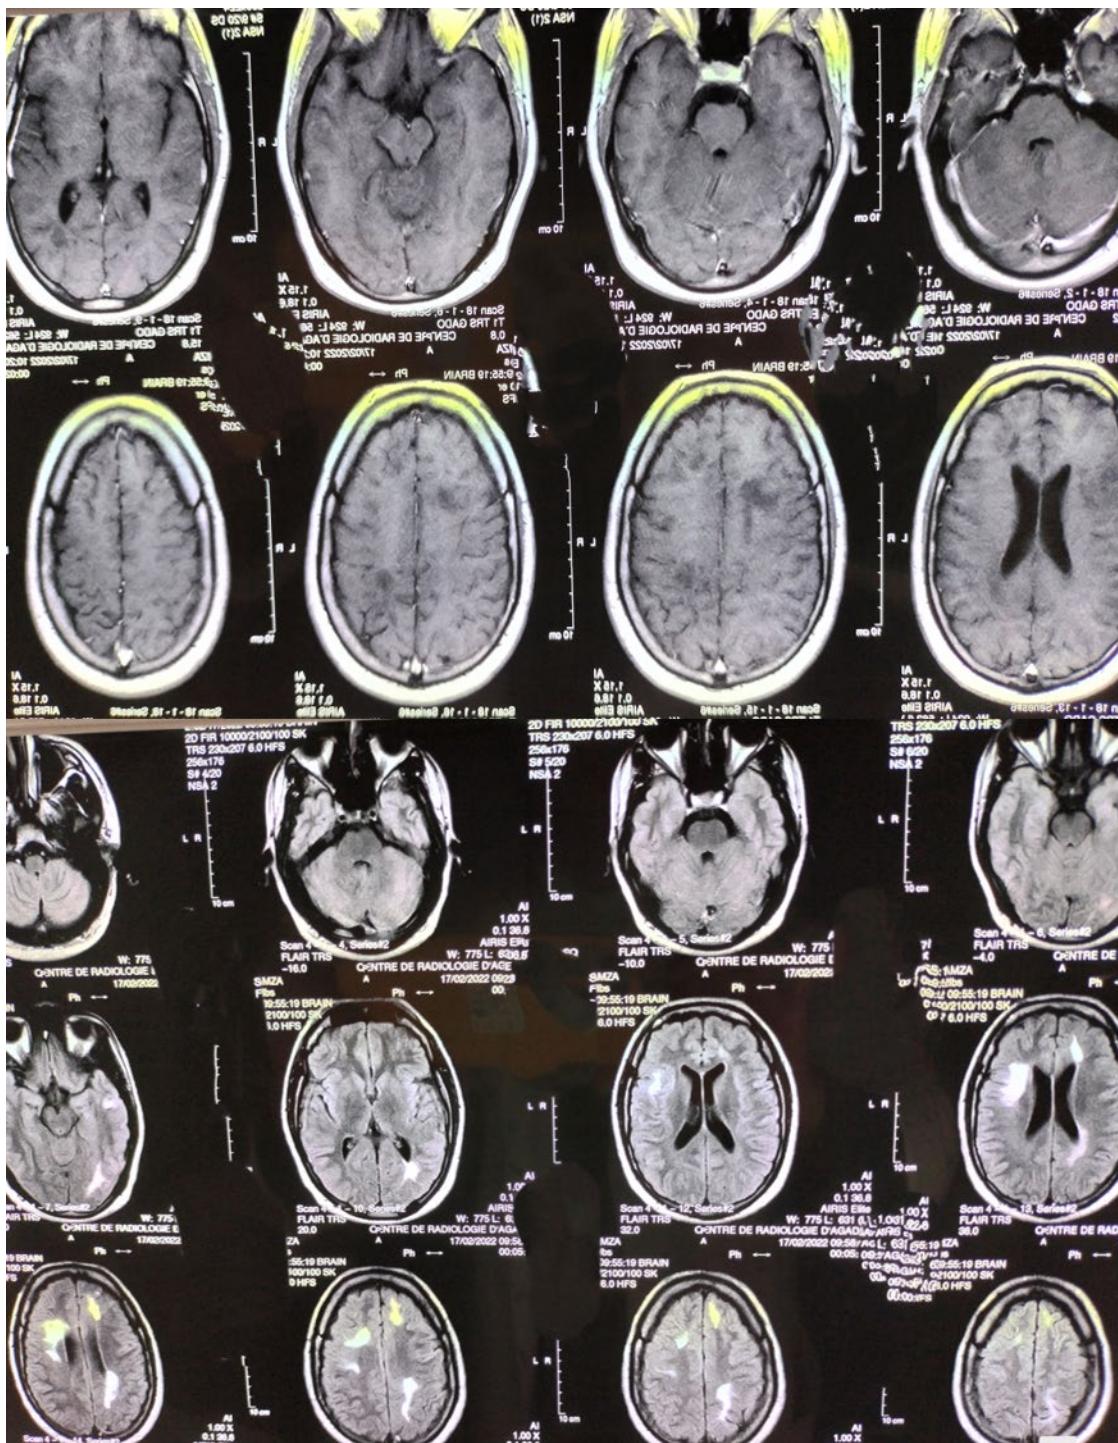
Brain MRI of a 21-year-old MOGAD patient, showing cortical and subcortical T1 hypointensity associated with T2/FLAIR hyperintensity, with no contrast enhancement. The optic nerves are unaffected.
